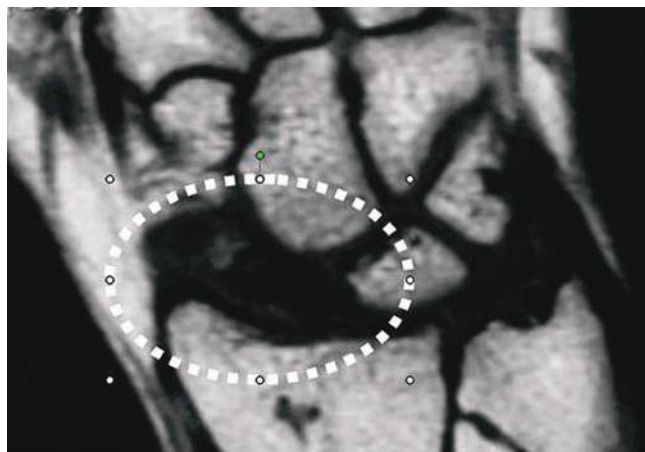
T1-weighted magnetic resonance imaging shows perfused bone as white. In this patient, there is the absence of whiteness where the scaphoid should be (*dashed circle*), consistent with avascular necrosis.
